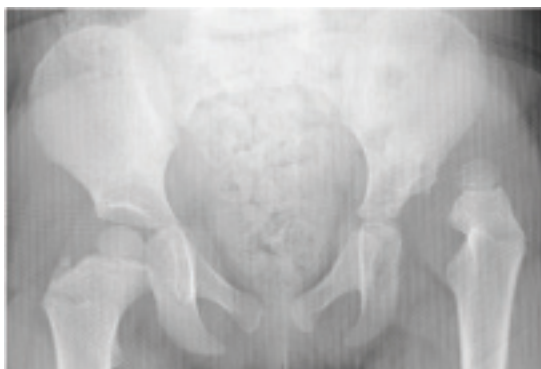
A plain radiograph demonstrating a dislocated hip in a 2-year-old. Note the smaller ossification center of the proximal femur and the upsloping, shallow acetabulum indicating existing dysplasia.
